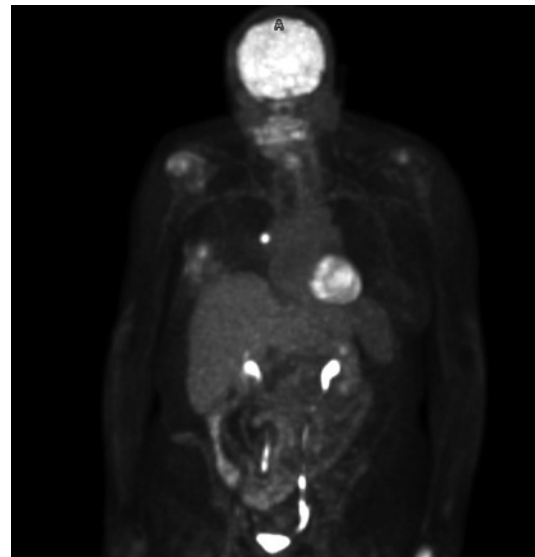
Initial staging ¹⁸F-FDG-PET scan of the patient showing region of ¹⁸F-FDG uptake in the right lung, right breast, and axilla. PET, positron emission tomography.
